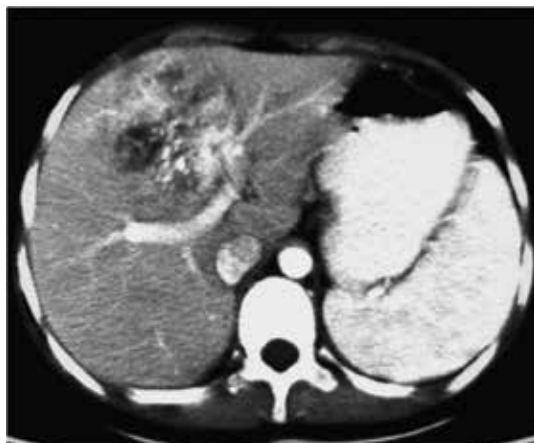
CT and three-dimensional reconstructed liver of PRETEXT II hepatoblastoma resectable at diagnosis (white arrow).
